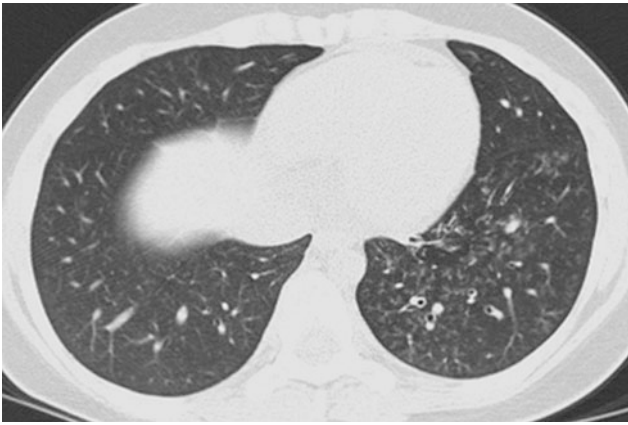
Atypical mycobacterial infection. An axial chest CT image in a 14-year old with a history of large cell lymphoma and bone marrow transplantation demonstrates extensive “tree-in-bud” opacities of the left lower lobe
